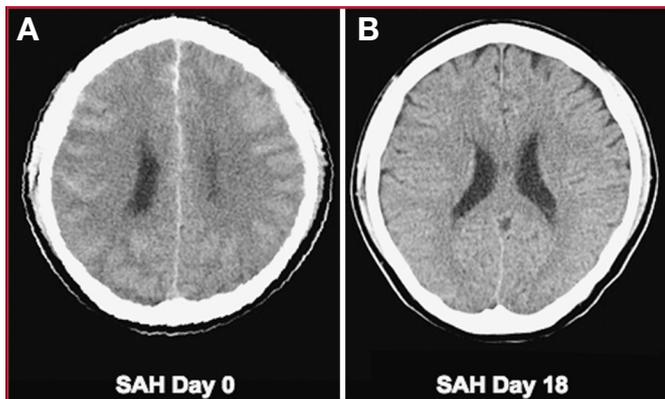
A, admission CT scan (SAH Day 0) showing global edema in a 55-year-old man with a Hunt and Hess Grade V SAH from a left anterior communicating artery aneurysm that was clipped. Note the complete effacement of all convexity sulci and presence of “finger-like” extensions of white matter lucencies to the cortical surface. B, a follow-up scan on SAH Day 18 showed complete normalization of the CT findings. (Reprinted with permission from Claassen J, Carhuapoma JR, Kreiter KT, Du EY, Connolly ES, Mayer SA: Global cerebral edema after subarachnoid hemorrhage: Frequency, predictors, and impact on outcome. *Stroke* 33:1225–1232, 2002 [19].)
